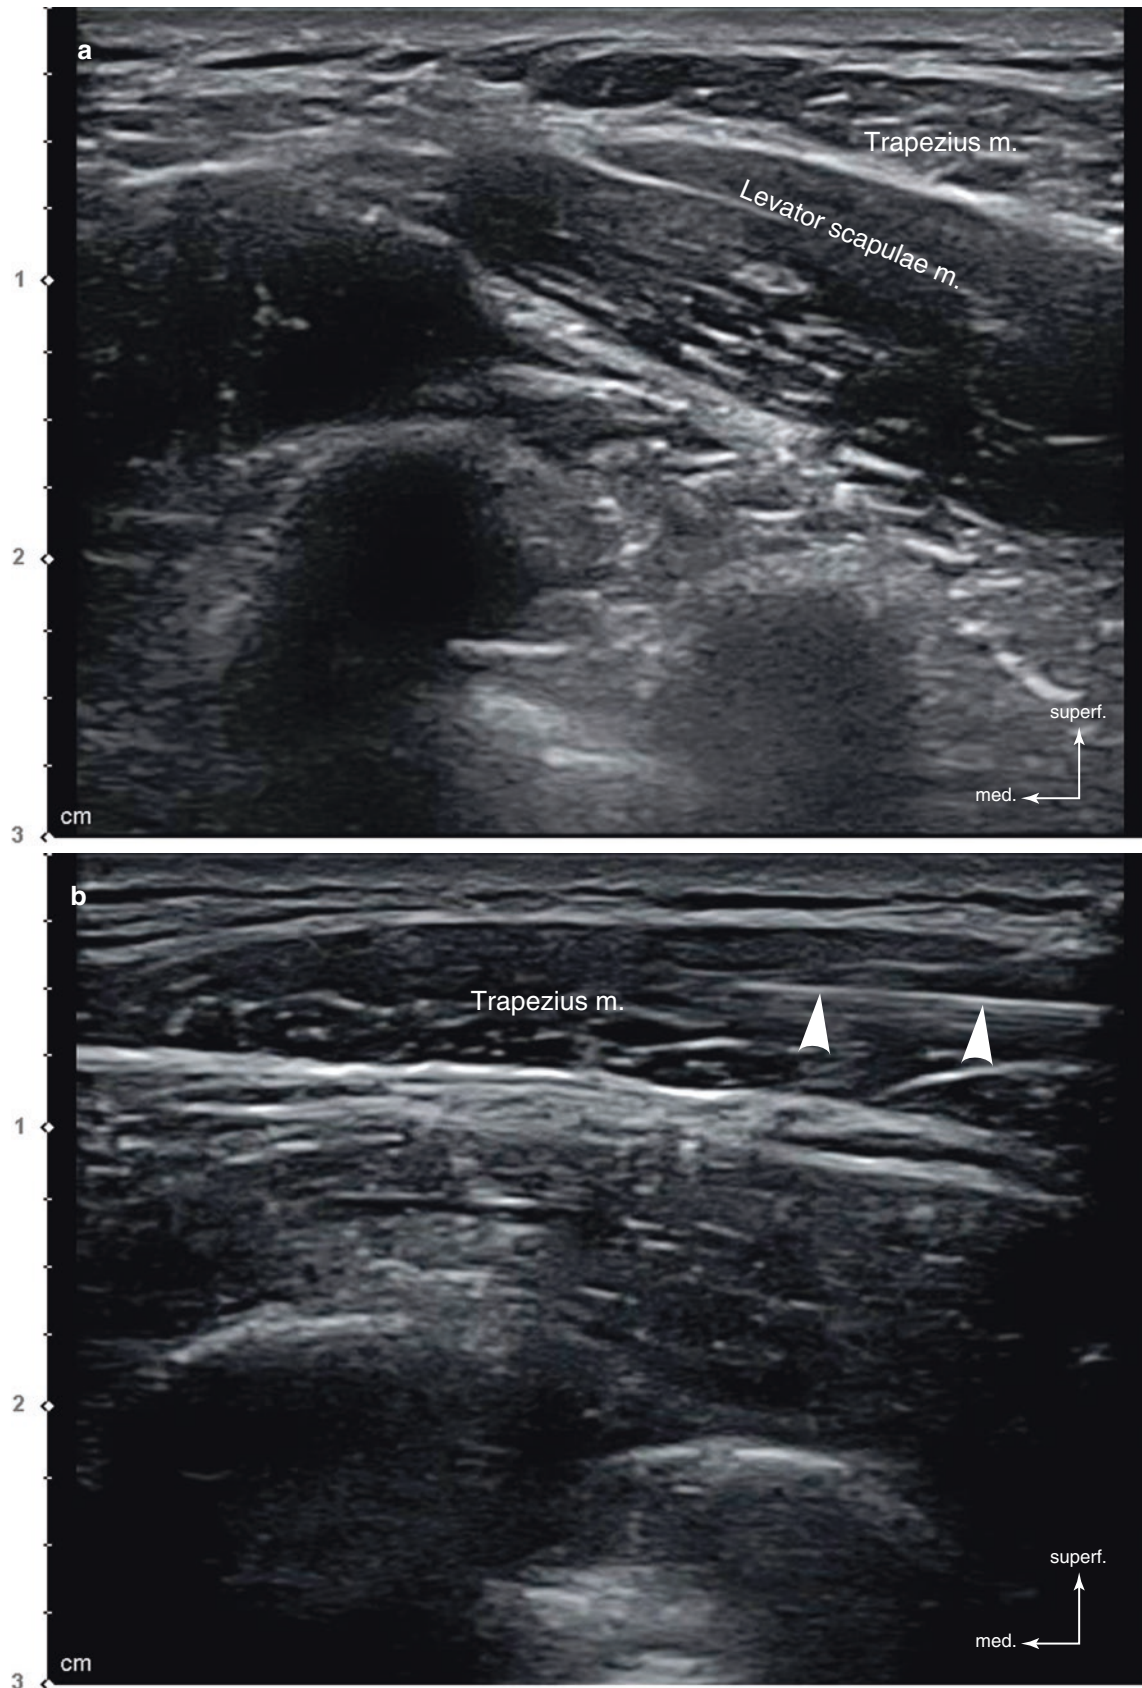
Ultrasonography of the upper shoulder. (a) B mode (transverse view, 15 MHz by linear transducer) and (b) ultrasonography-guided botulinum toxin injection to the trapezius muscle (in-plane), B
